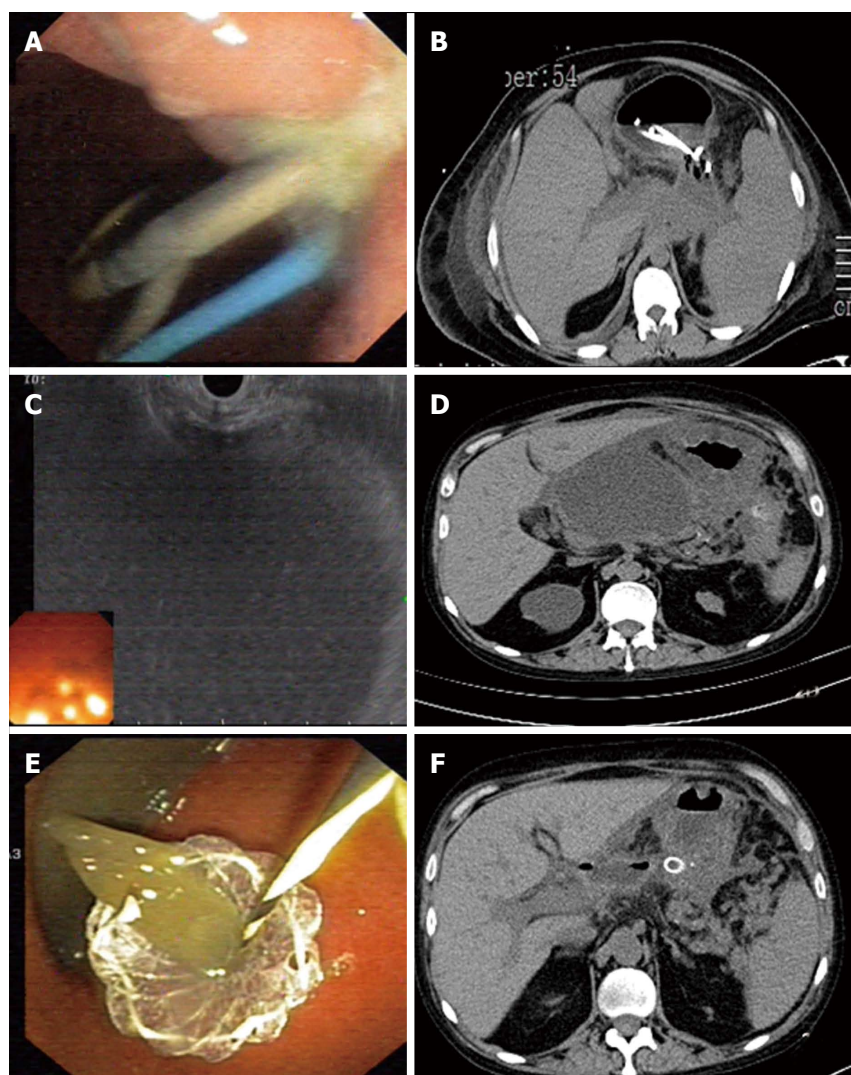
Placement of double pigtail plastic stent and nasocystic drain (A), computed tomography view of pancreatic fluid collections after insertion of stent and nasocystic drain (B), endosonographic view of pancreatic fluid collections before drainage (C), computed tomography view of pancreatic fluid collections before drainage (D), Placement of NAGI stent into pancreatic fluid collections (E), computed tomography view after placement of NAGI stent (F).
